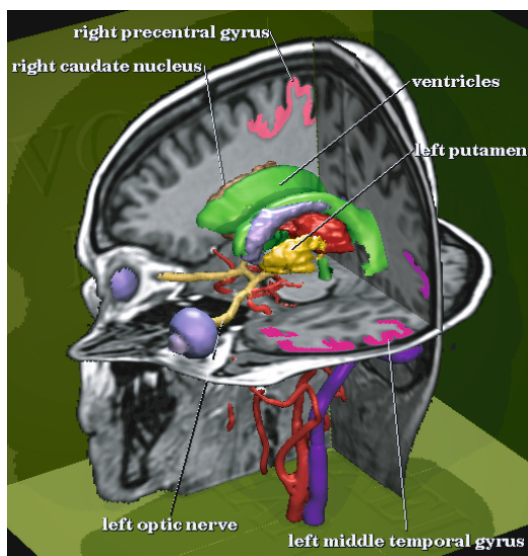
Brain from MRI. Original intensity values are mapped onto the cut planes.
